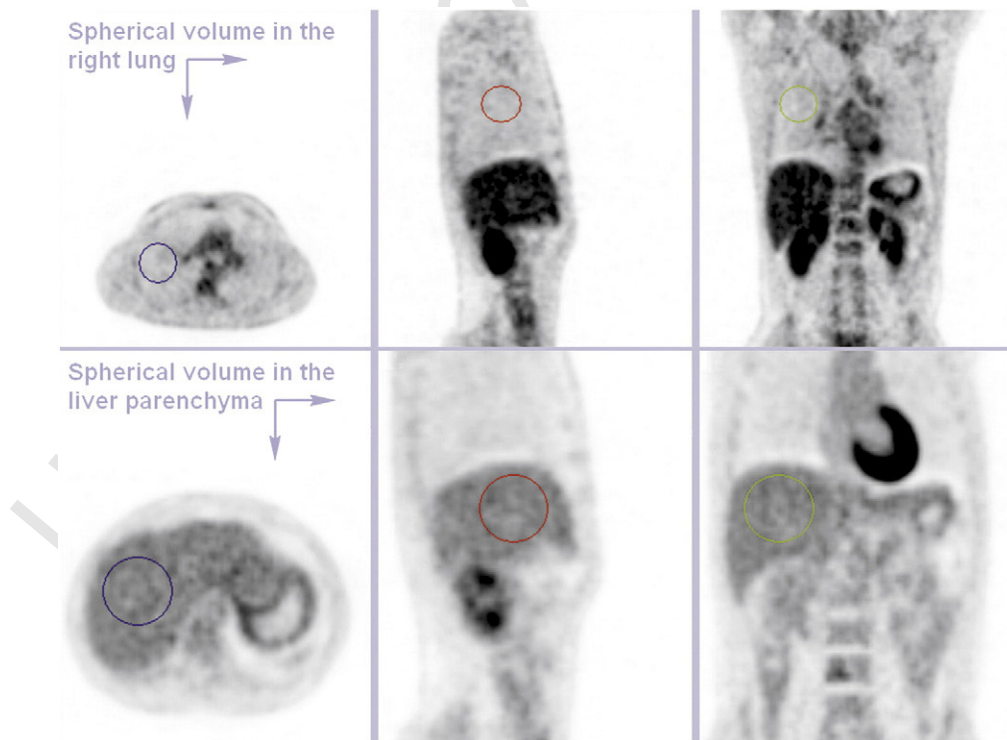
SUVmax in a spherical volume (6–8 cm in diameter) in the right lung was put into relation with SUVmax in a spherical volume (9–10 cm in diameter) in the reference liver parenchyma to set up the SUVmaxPULMO/SUVmaxHEPAR index. Considering the topographical differences between the lungs and the liver, we were more limited in demarcating the volume of interest in the lung parenchyma, which therefore has smaller diameter.
